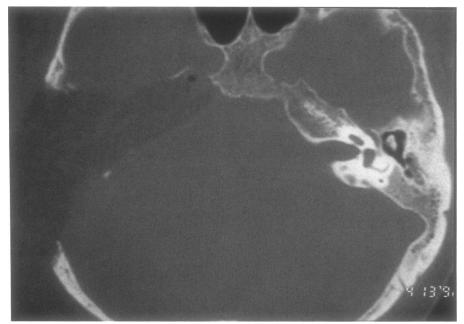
Massive labyrinthine cholesteatoma. Postoperative CT, axial section. All the temporal bone is absent and the cavity is completely filled with abdominal fat. The cavity is free from recurrence.
